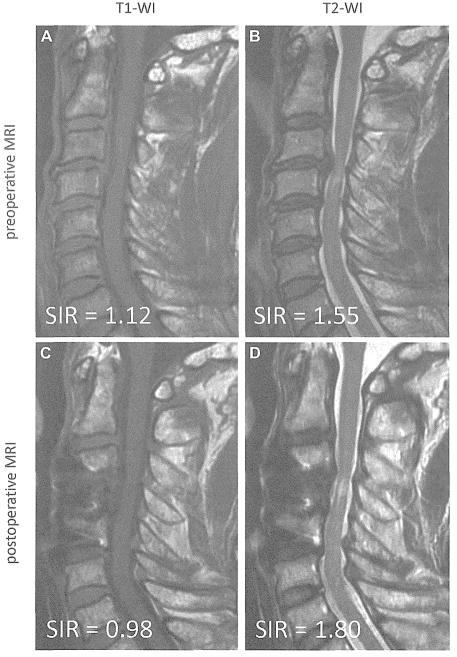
A representative case with changes in SIR on T1-WI from >1 to <1. A 62-year-old woman with cervical spondylotic myelopathy showed 28.6% (from 10 to 12) neurologic deterioration at follow-up. (A) Preoperative mid-sagittal T1-weighted MRI, (B) preoperative mid-sagittal T2-weighted MRI shows intramedullary increased signal intensity at C3–C4 level, (C) postoperative mid-sagittal T1-weighted MRI, and (D) postoperative mid-sagittal T2-weighted MRI shows decrease of signal intensity on T1-WI and increase on T2-WI. MRI, magnetic resonance imaging. SIR, signal intensity ratio; WI, weighted image.
